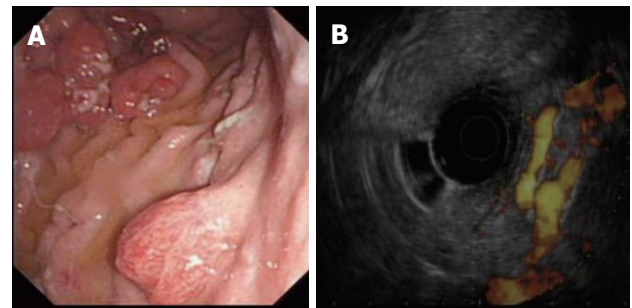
Endoscopic image of gastric irregular submucosal lesion. A: Gastric irregular submucosal lesion in a patient with portal hypertension; B: The same lesion examined under color Doppler endoscopic ultrasound. The submucosal lesion was hypervascular and represented a gastric varix.
